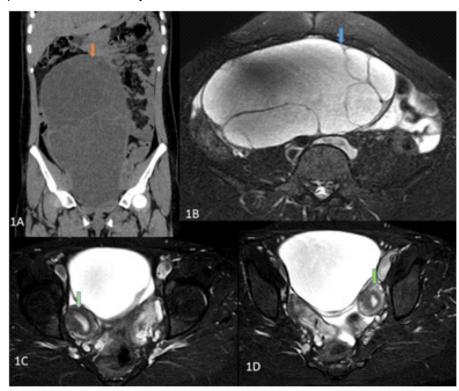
1A –CT-abdomen coronal image and 1B- T2 SPAIR axial image showing mucinous right ovarian cystadenoma (orange and blue arrows). 1C and 1D- T2 SPAIR axial images showing two separate divergent uterine horns (green arrow) with separate cervices with normal bilateral endometrial thickness representing uterine didelphys
